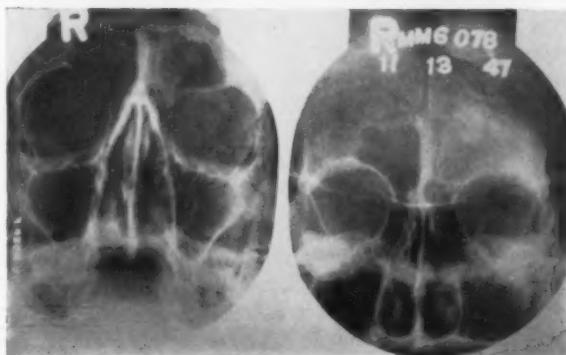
Roentgenogram of the patient with fistula and corneal opacity, showing clouding of the left frontal sinus, thickening of its walls, and marked condensing osteitis surrounding it.
